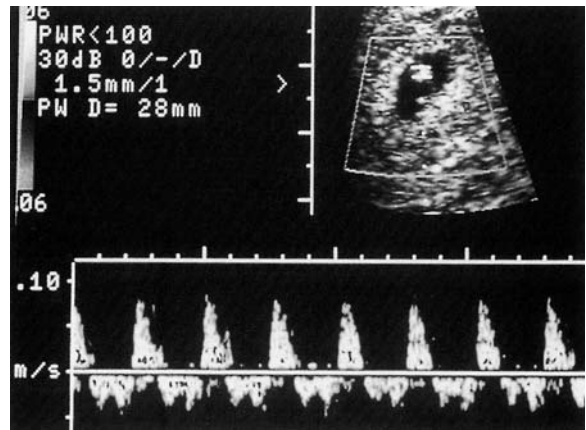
Spectral Doppler waveforms from the pulmonary artery (a) and aorta (b). Both waves show rapid accelerations. The deceleration slope of the pulmonary artery, however, is slightly less steep than that of the aorta
